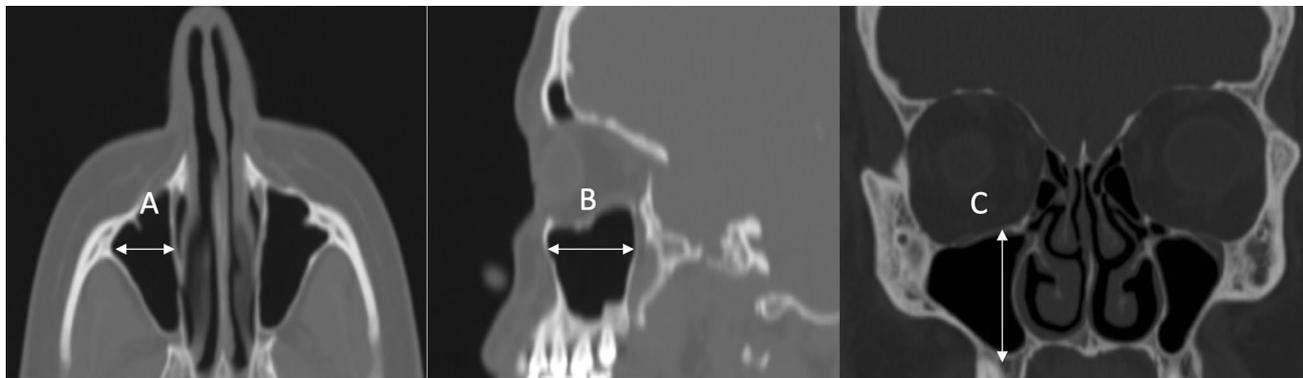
Paranasal sinus computed tomography sections; *A* width of the evaluated sinus in an axial section, *B* length of the evaluated in sagittal section and *C* height of the evaluated sinus in coronal section
